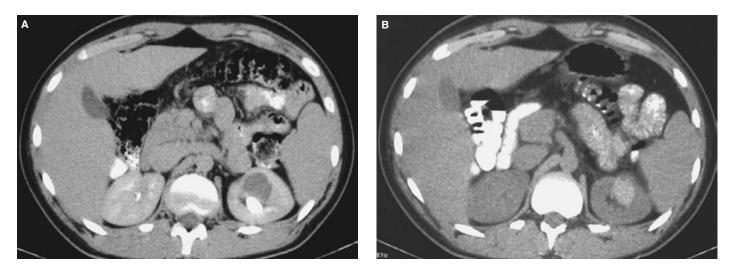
(A) Axial CT shows a well-defined fluid-containing cyst in the left kidney. (B) Following an episode of acute flank pain, CT reveals a generalized increased attenuation value of the mass, suggestive of acute hemorrhage.
